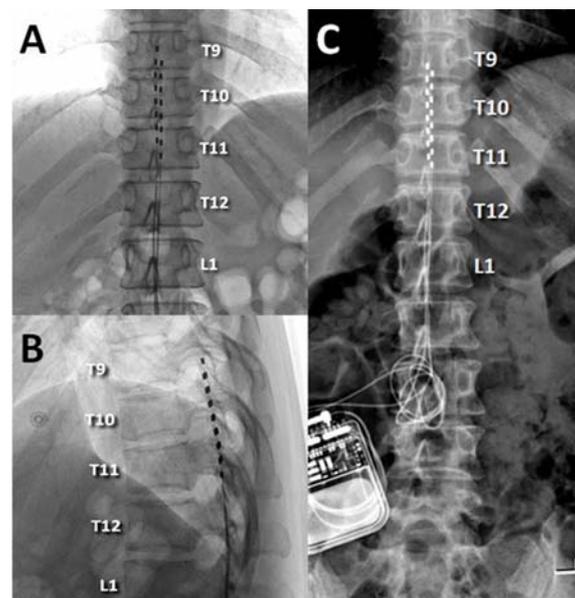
Spinal radiograph following implantation of electrodes for spinal cord stimulation: (A) anteroposterior spinal radiograph in the trial period showing bilateral electrodes located at the T9-T11 vertebral levels; (B) lateral spinal radiograph in the trial period showing the electrodes located at the posterior portion of the spinal canal; (C) anteroposterior spinal radiograph following implantation of a pulse generator showing both electrodes connected to the pulse generator.
